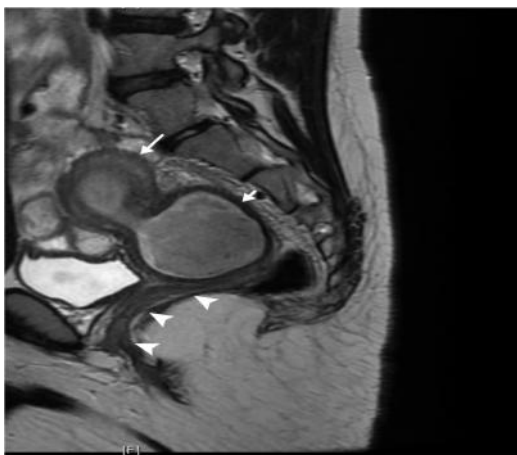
This Short Axis T2-weighted MRI fast spin-echo image shows two separate uterine bodies, right is distended with blood-hematometra (long arrow) and left normal uterus (open arrow).
